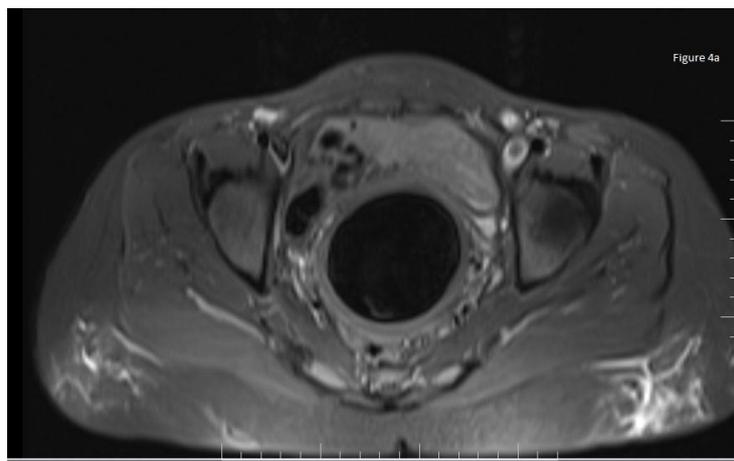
MRI – showing hematometra nullified on axial STIR.
